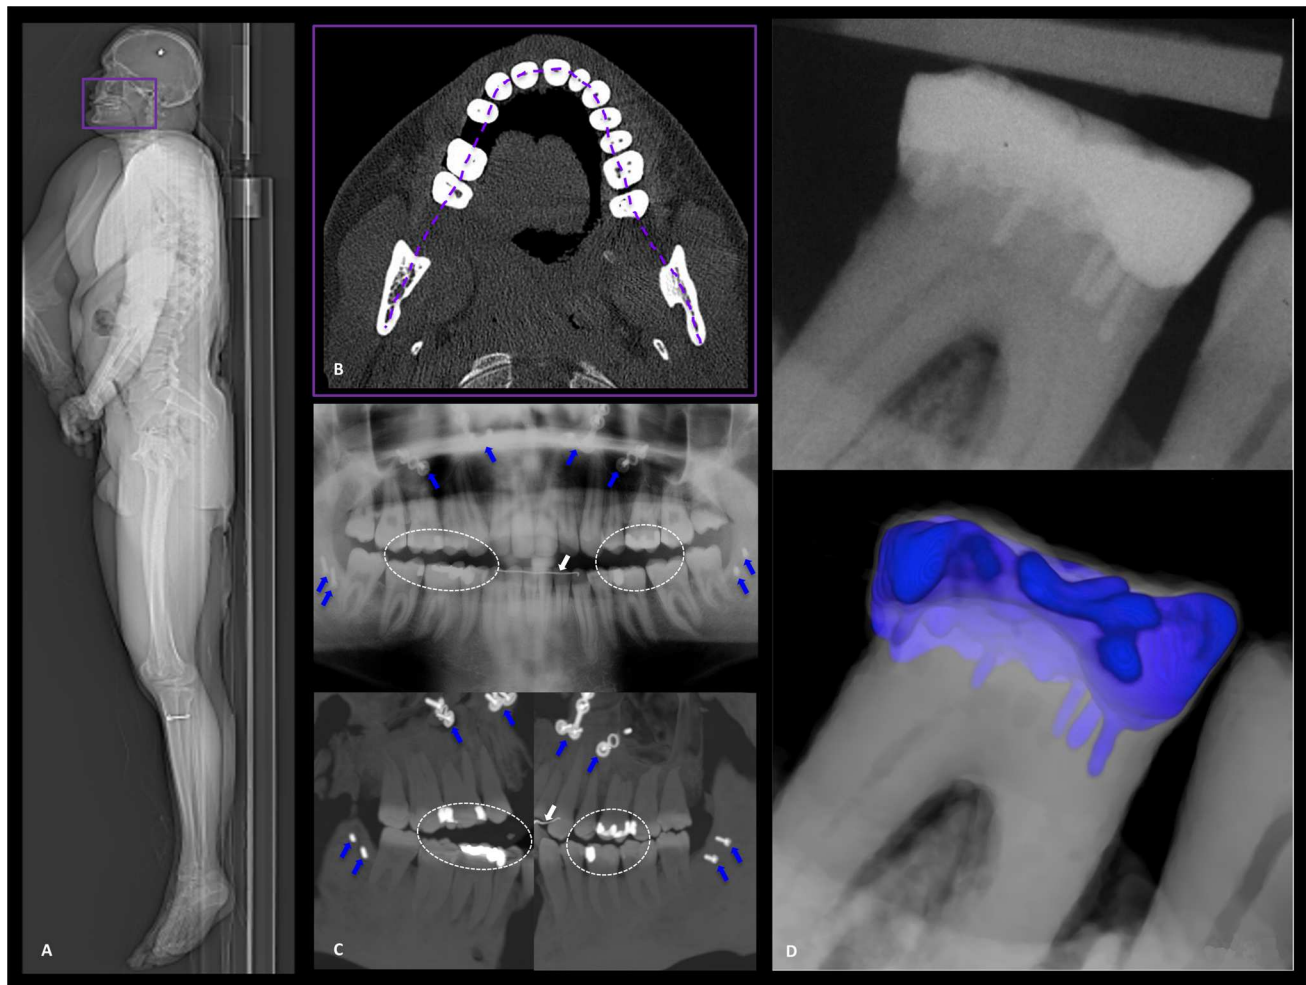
Add-on to PMCT protocol: Dental. a Scout view of the dental PMCT in lateral orientation (the small, adjusted FoV is marked by the *purple planning rectangle*). b Axially aligned slices in a hard kernel and dental window, with high resolution and a slice thickness of 0.4 mm. This image displays the curved multiplanar reconstruction that is used to create a “virtual” orthopantomogram (OPT), similar to antemortem OPTs of the complete jaw. c Upper row image: antemortem OPT depicting extensive osteosynthetic work in the maxilla and mandible (indicated by the *bold blue arrows*), dental retainer dorsal to the front teeth of the jaw (*bold white arrow*) and dental fillings (*white circle*). *Lower row image, left* postmortem
